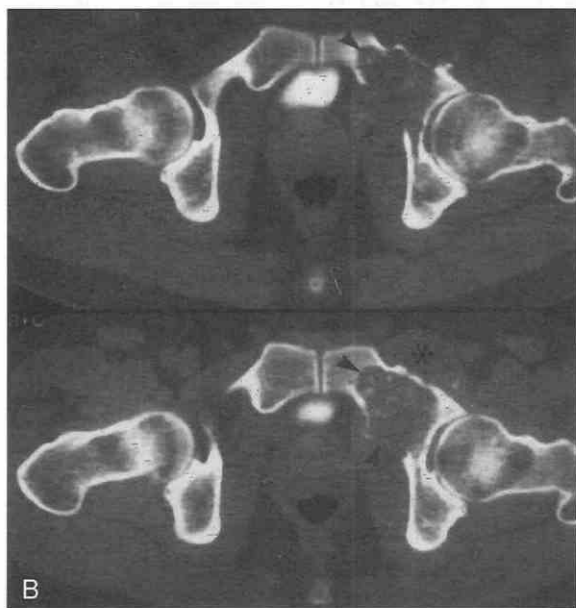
Chondrosarcoma of the left acetabulum in a 30-year-old man with vague hip pain of several months' duration. *A*, Radiograph of the pelvis shows subtle aggressive bone destruction of the medial left acetabulum with permeation of the iliopectineal line (curved arrows). *B*, CT scans show bone destruction with chondroid matrix formation (large arrowheads) and an associated soft tissue mass (asterisk). *C* and *D*, Coronal T1-weighted MR image (*C*) and axial T2-weighted MR images (*D*) reveal marrow replacement (small arrowheads) and soft tissue mass (asterisk), which becomes high signal intensity on the long TR/TE image (*D*). The soft tissue mass has invaded the hip joint, as evidenced by the fact that the soft mass abuts the femoral head (arrows).
